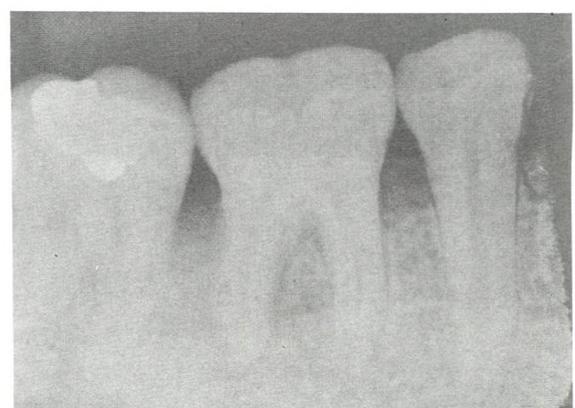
Pre operative and post operative periapical radiographs of 46 region
